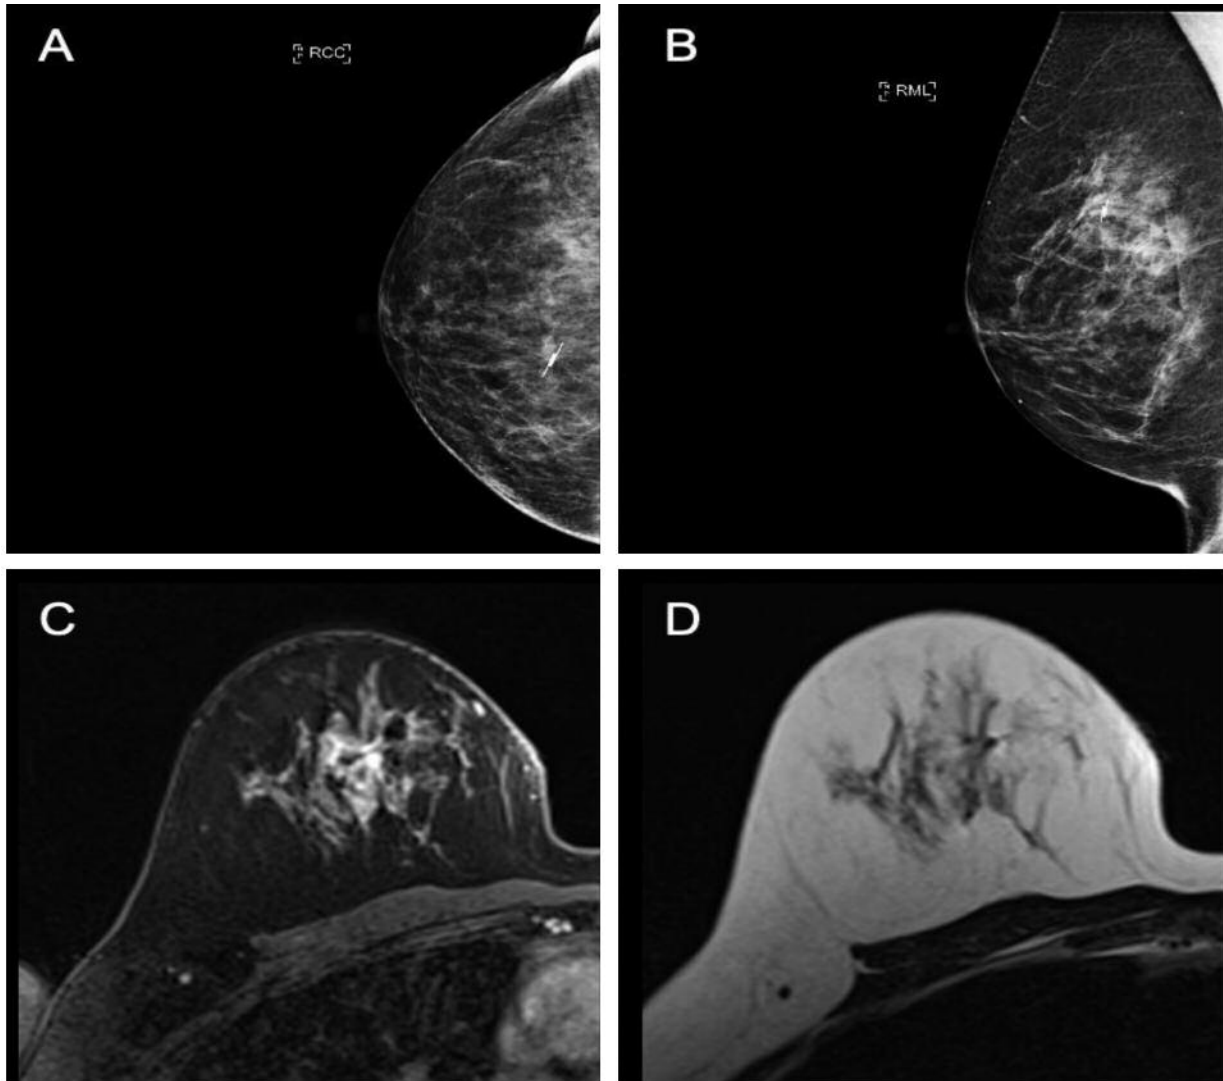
Minimal magnetic resonance imaging (MRI) void signals at the site of reflector localizing the tumour in the upper inner quadrant of the right breast. A: Right craniocaudal mammogram view. B: Right mediolateral mammogram view. C: T1-Weighted non-subtracted MRI image post contrast. D: T2-Weighted MRI image showing minimal MRI void.
